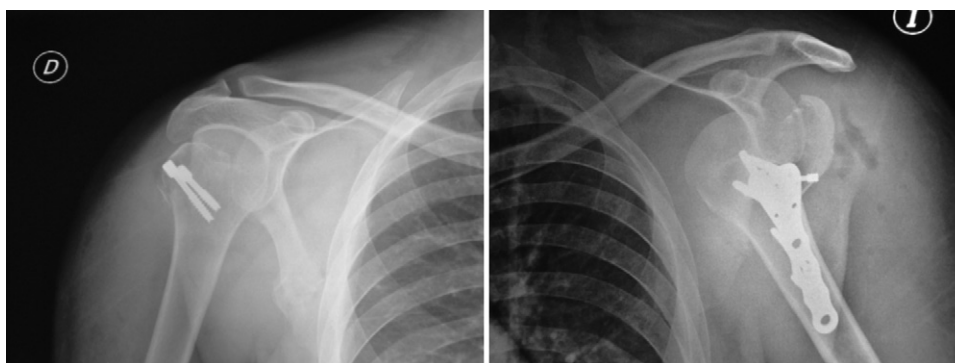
Shoulder X-ray. D: right; I: left.
